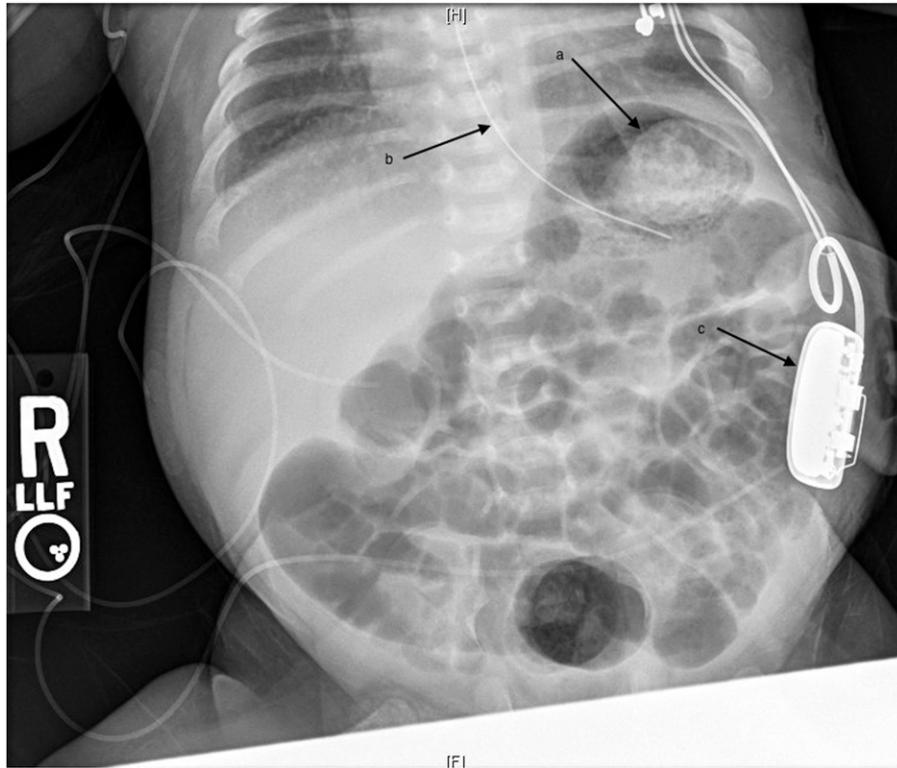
A frontal abdominal radiograph of the patient reveals a soft tissue density mixed with air in the fundus of the stomach (a). A nasogastric tube (b) and cardiac pacemaker (c) are visible.
